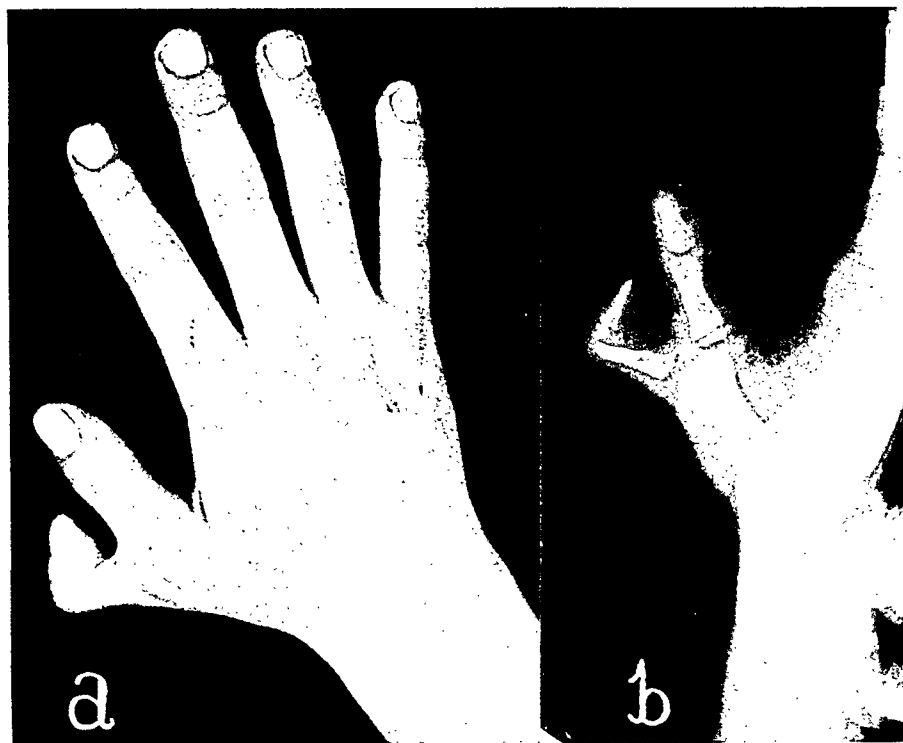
a*, dorsum of right hand, showing accessory thumb (polydactyism). *b*, roentgenogram showing two phalanges in the accessory thumb.
